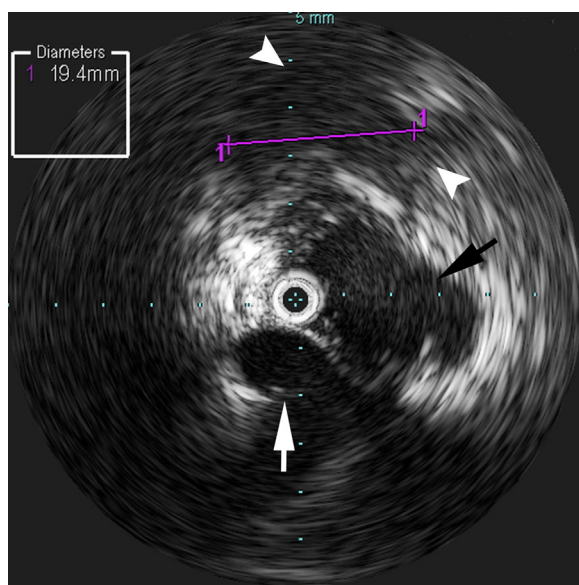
Axial image from IVUS at same position as Figure 1D revealing a hypoechoic mass (between white arrowheads) anterior to the common bile duct (black arrow). Also noted is the hepatic artery (white arrow), which was used for orientation of the IVUS. IVUS, intravascular ultrasound.
